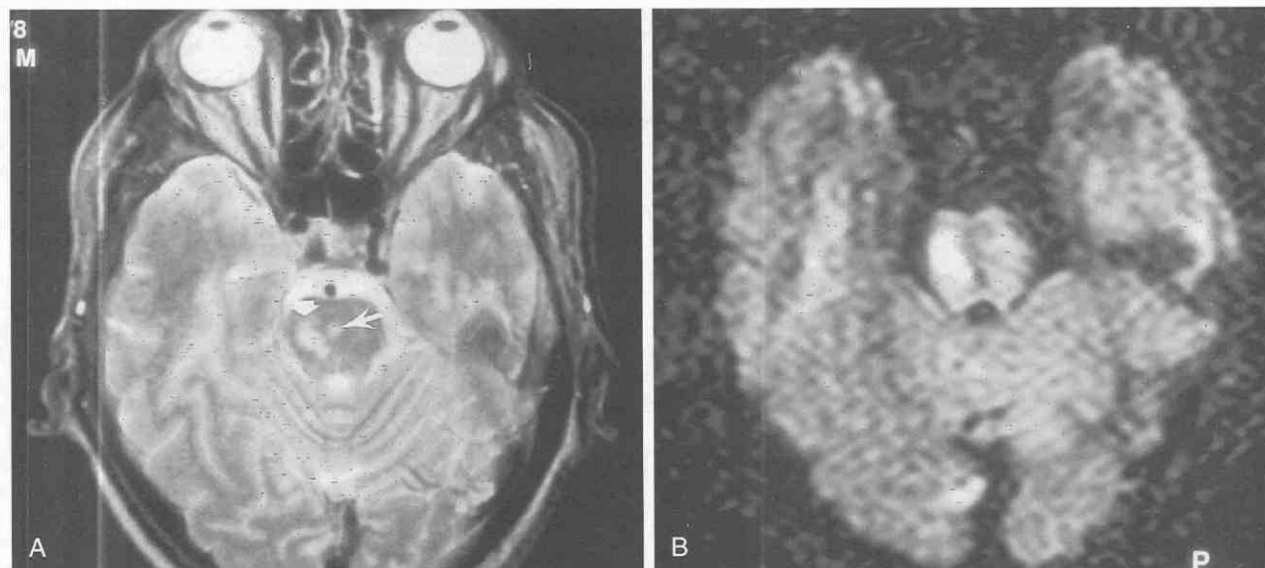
The patient is a 59-year-old man with acute stroke. A, T2-weighted axial image shows increased signal focally within the central (arrow) and lateral (small arrow) portions of the pons. B, Axial diffusion-weighted image shows hyperintense signal within the lateral abnormality, suggesting that only this area represents acute infarct. The smaller, central hyperintensity, presumably, represents a more remote ischemic lesion.
